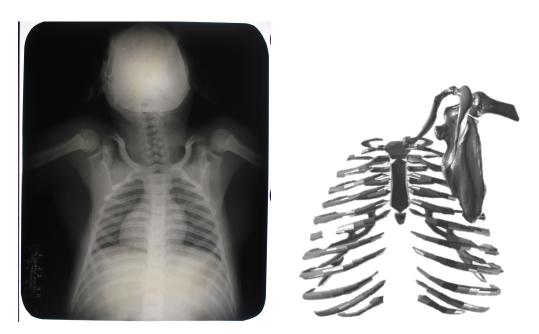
X-ray of upper extremity of an anesthetized chimpanzee (left), showing the faint outline of the scapula and clavicle. These x-rays were used to guide the placement of the scapula and clavicle in the digital model (right)
